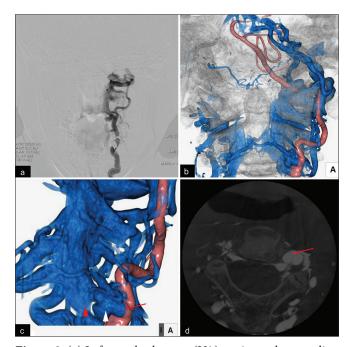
(a) Left vertebral artery (VA) angiography revealing vertebral artery- external vertebral venous plexus (VA-EVVP) fistula at the C2 level and venous drainage into the external VVP (EVVP), internal VVP (IVVP), internal jugular vein, and transverse sinus. (b, c, d) Three-dimensional rotational angiography and cone-beam computed tomography of the VA showing a single hole of a large fistula (arrow), EVVP (white arrowhead), and IVVP (red arrowhead).
